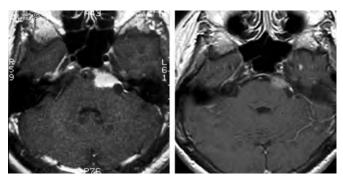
Preradiosurgical axial MRI scan of a petroclival meningioma (left) and 10-year follow-up MRI showing tumor volume regression (right). The patient had no cranial neuropathy.
